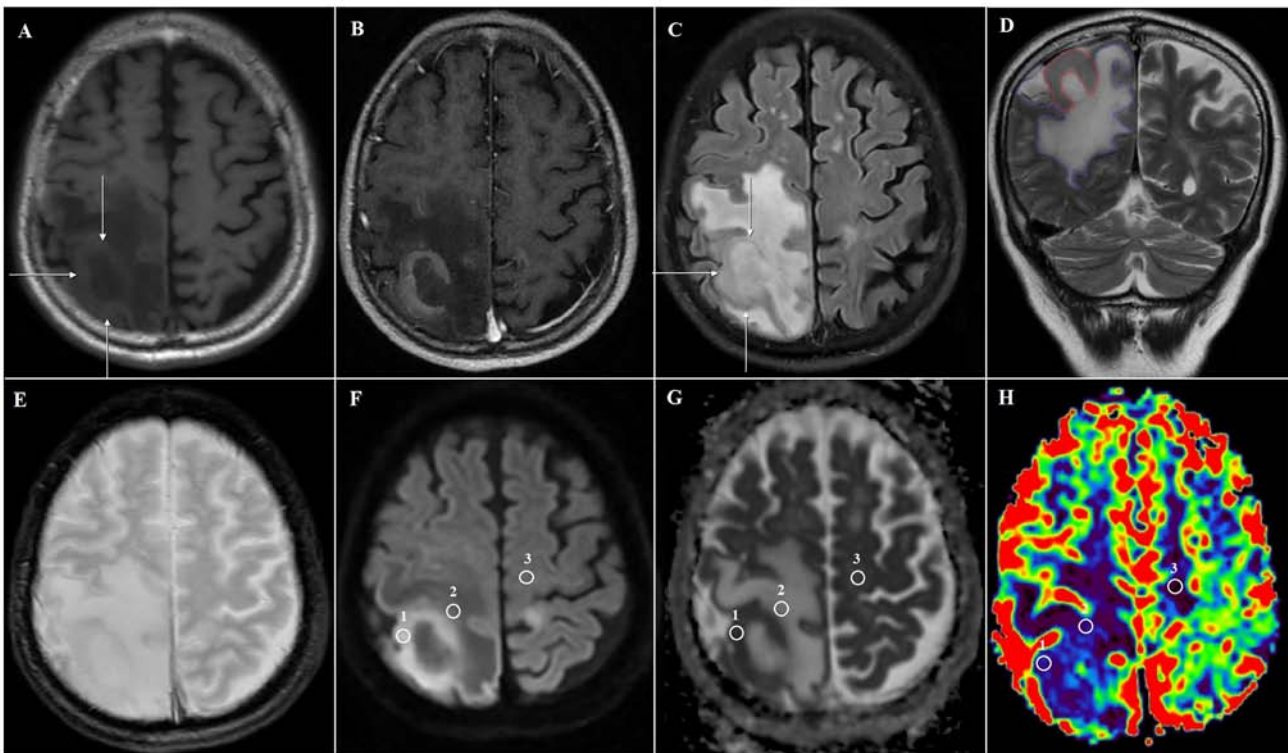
A 70-year-old man with a PCNSL. (A) The MRI shows a mass (straight arrows) in the right parietal lobe. A comparison of (A) pre- and (B) post-contrast T1W images shows a very strong and homogeneous open-ring enhanced tumor. (C) Axial FLAIR and (D) coronal T2W images with two manually drawn polygonal lines that include the entire peritumoral brain edema (blue line) and tumor (red line); the peritumoral volume is greater than the tumor volume. (E) The conventional T2\* GE image shows no intertumoral hemorrhage. (F) Axial DWI and the corresponding (G) ADC map show a diffusion-restricted lesion. (H) The CBV color map shows a lower signal intensity in the tumor than in the normal white matter; three ROIs (circles) were placed in the solid tumor component (ROI 1), peritumoral region (ROI 2), and abnormal white matter (ROI 3). The minimum ADC was  $0.63 \times 10^{-3} \text{ mm}^2/\text{s}$  in the solid tumor (ADCt),  $1.57 \times 10^{-3} \text{ mm}^2/\text{s}$  in the peritumoral edema (ADCe), and  $0.69 \times 10^{-3} \text{ mm}^2/\text{s}$  in the normal white matter (ADCn). The rCBV value was 0.68 in the solid tumor (rCBVt), 0.54 in the peritumoral edema (rCBVe), and 0.37 in the normal white matter (rCBVn). PCNSL, primary central nervous system lymphoma; MRI, magnetic resonance imaging; T1W, contrast-enhanced T1-weighted; FLAIR, fluid-attenuated inversion recovery; DWI, diffusion-weighted; ADC, apparent diffusion coefficient; ADCt, solid tumor ADC value; ADCe, peritumoral edema ADC value; CBV, cerebral blood volume; rCBV, relative cerebral blood volume; rCBVt, solid tumor rCBV value; rCBVe, peritumoral edema rCBV value.
